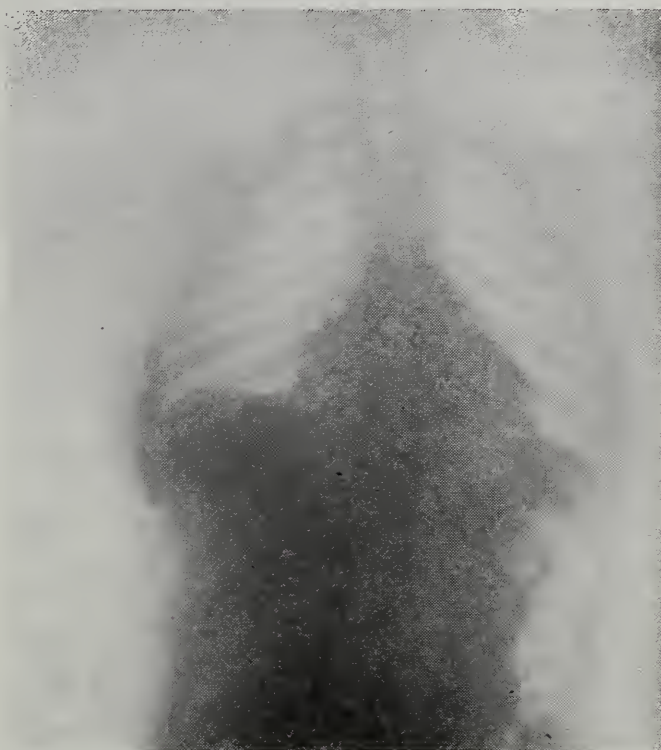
This x-ray shows the segmental absence of ossification in both clavicles with assymetry of the rib cage. The lower cervical and upper dorsal neural arches are unclosed.
